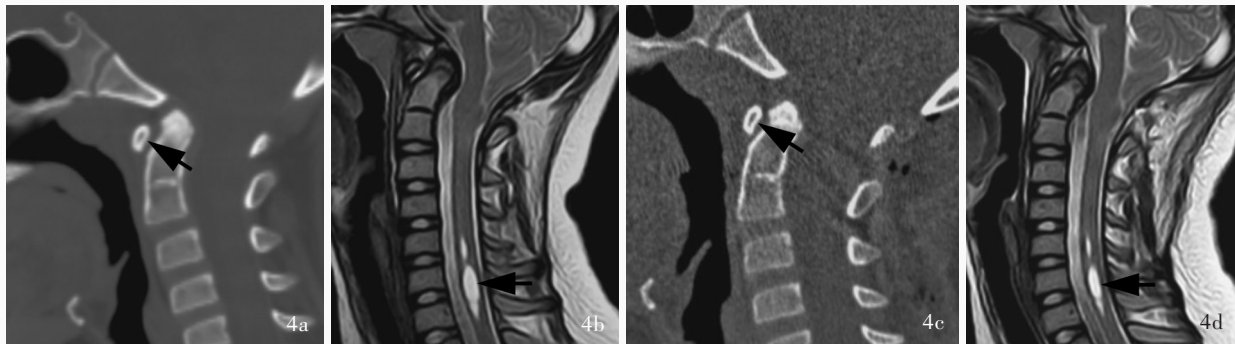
男性患者, 15 岁, 临床诊断为 Goel B 型颅底凹陷症, 于滑轨式牵引头架牵引下行后路寰枢关节间撑开复位融合术。手术前后影像学所见 4a, 4b 术前矢状位三维重建 CT 和 T₂WI 显示颅底凹陷、寰椎水平颈髓受压, 小脑扁桃体下疝伴脊髓空洞形成(箭头所示) 4c, 4d 术后 7 d 矢状位三维重建 CT 和 T₂WI 显示颅底凹陷及颈髓受压程度明显改善, 脊髓空洞缩小, 斜坡枢椎角及延髓脊髓角较术前增大(箭头所示)
